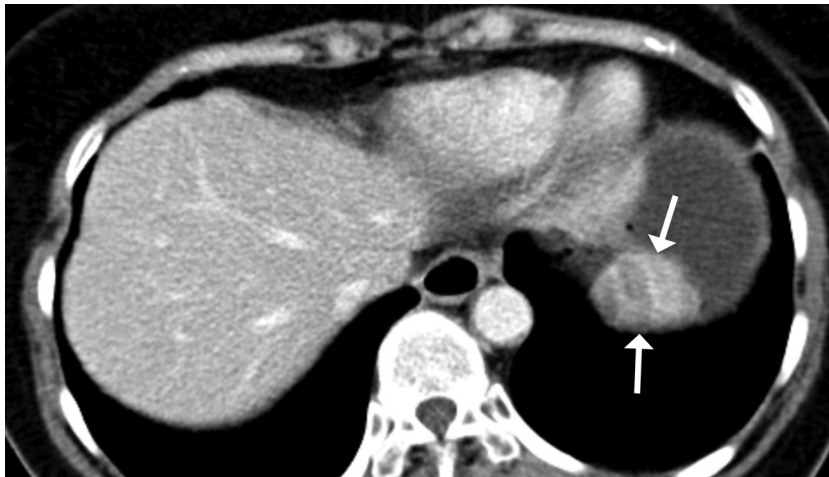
Preoperative CT image of the first tumour. Axial view.
